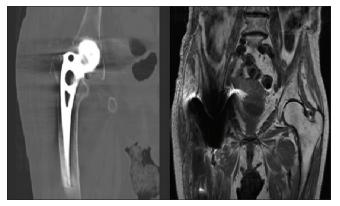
One patient underwent computed tomography for further peri-prosthetic evaluation not possible on magnetic resonance imaging due to significant susceptibility artifact. No acute complication demonstrated.
